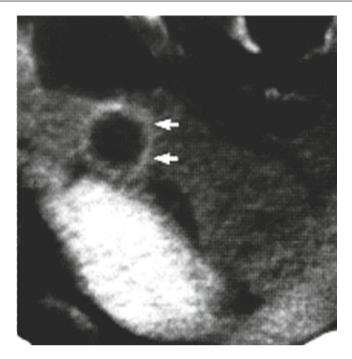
CT appearance of pancreatic RFA. A well-defined, enhancing, 2–3 mm rim surrounds the treatment focus (14 days after treatment) (arrows).
